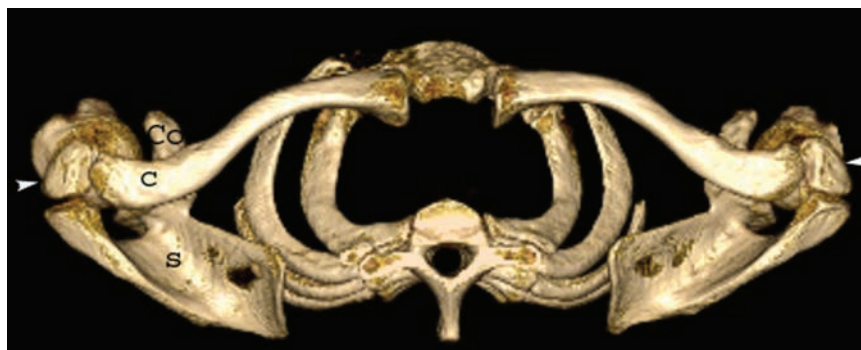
Volume-rendering multidetector computed tomography superior view shows the oblique course of the clavicle. Bilateral os acromiale (arrow) is seen. C, clavicle; Co, coracoid process; S, scapula.
